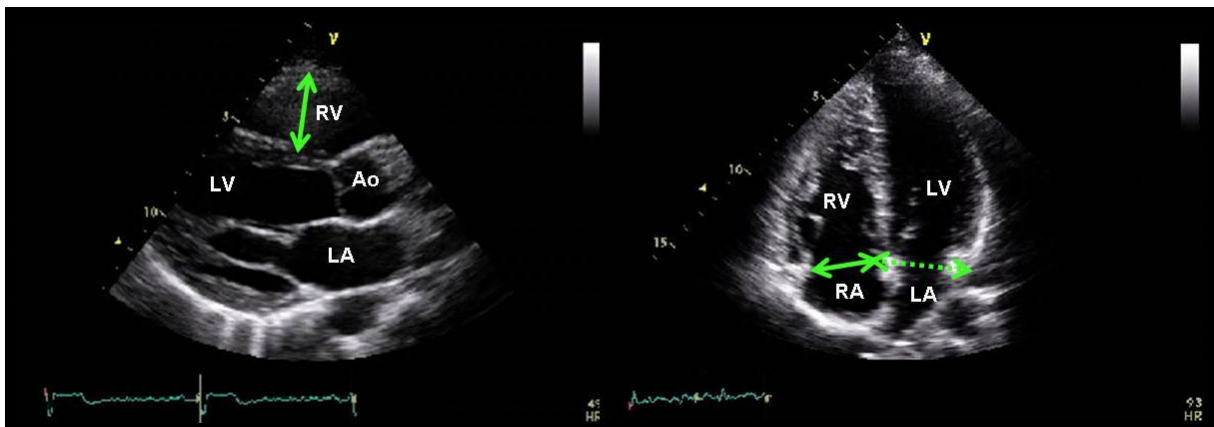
RV dimensions estimated in focused echocardiography. In the image on the left (PLAX view), the RV cavity dimension (arrowed, green) is estimated at end-diastole. In the image on the right (A4Ch view), the inlet dimension of the RV (solid green arrow) is compared with that of the LV (broken green arrow).
